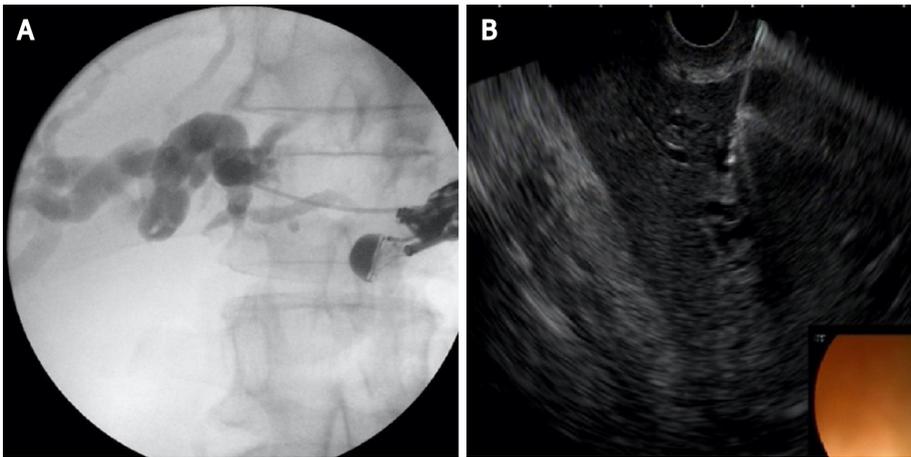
Left hepatic duct puncture and contrast injection. A: Cholangiogram; B: endoscopic ultrasound image.
